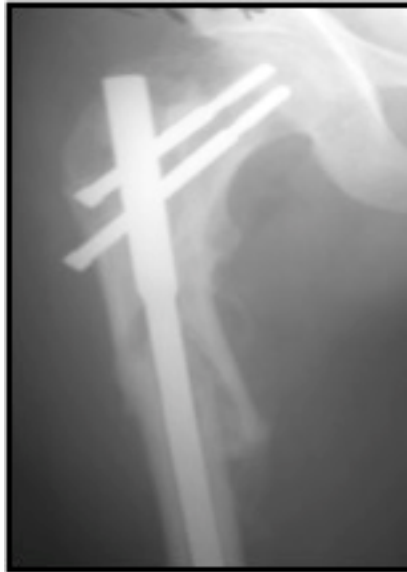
12 weeks follow up X-Ray
